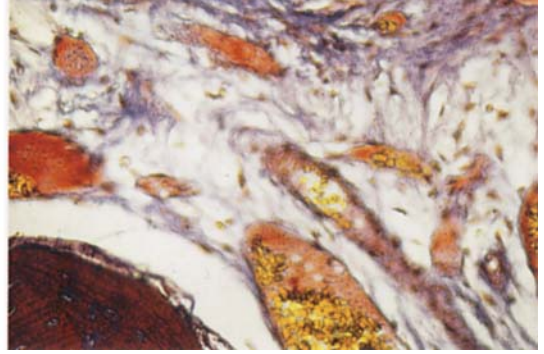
Section of bone marrow from the femoral head of a 61-year-old patient with intraosseous engorgement-pain syndrome (radiographically silent arthrosis). Invasive vascularized and edematous fibrous tissue (MSB, x250).
